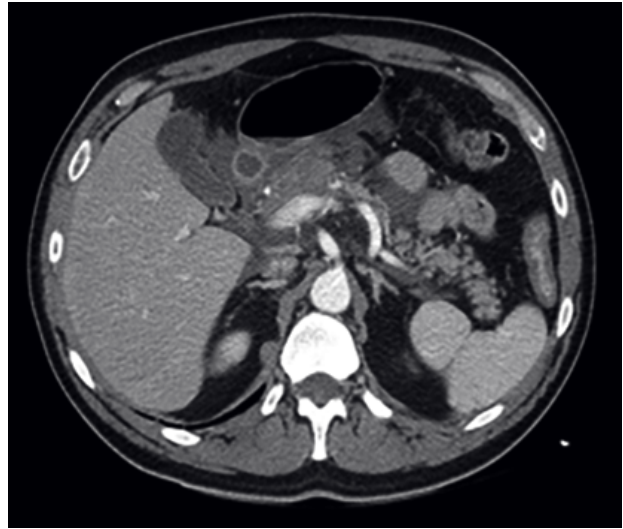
48-years-old man: severe acute pancreatitis CT-scan image. Acute pancreatitis characterized by large area of pancreatic swelling (cephalic) which is suitable for necrotic process. This is associated with peripancreatic fluid collections partly embedding vascular branches (celiac district, mesenteric-portal system) and occupy the para-renal space and the parietocolic lodge.
